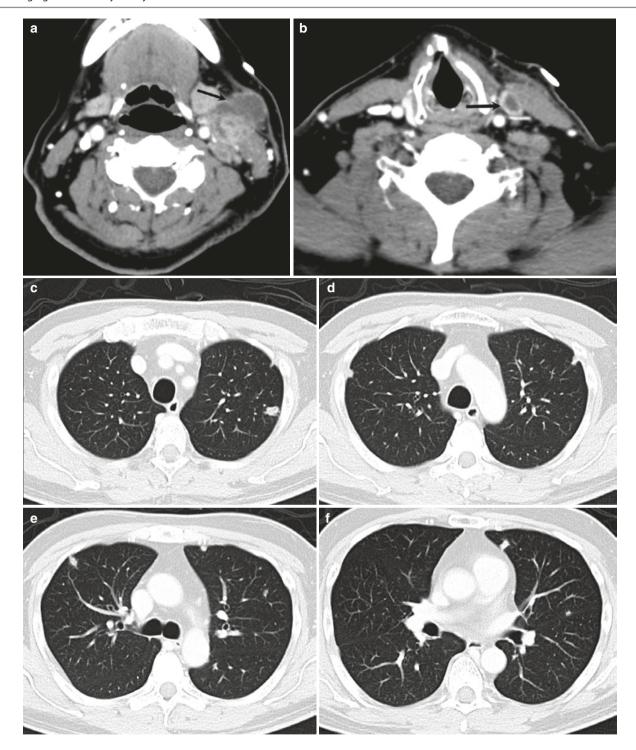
Lemierre's syndrome in a 39-year-old man. (a) Axial CT neck image shows left large suppurative nodal mass (arrow). (b) CT image from the lower neck shows thrombophlebitis of the left internal
